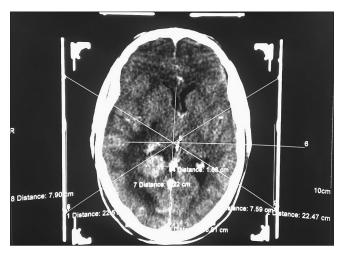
Computed tomography scan showing the target with fiducial markers and coordinates along x, y, z axis
